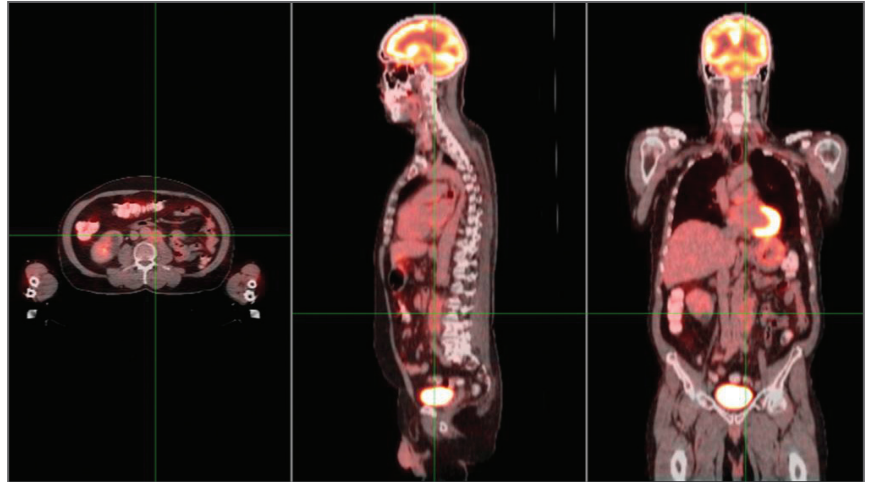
PET-CT scans obtained 2 months after CyberKnife treatment demonstrating a significant reduction in the FDG uptake in the region of the confluent left para-aortic adenopathy.
